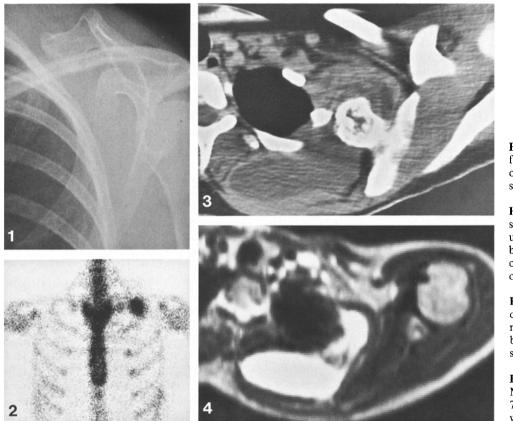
A region of left scapula from posteroanterior radiograph of chest shows exostosis of scapular blade
